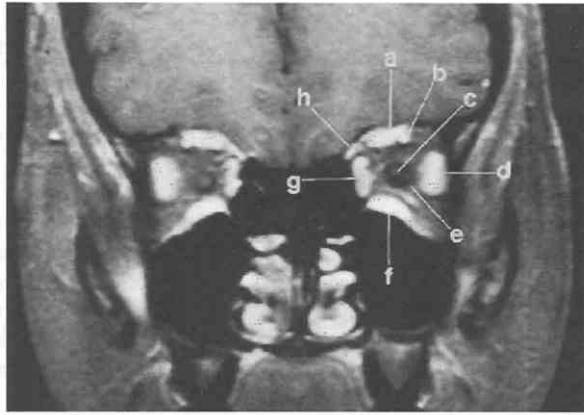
Coronal T1-weighted MRI study with fat saturation: normal anatomy. A, Superior rectus/levator palpebrae superioris complex. B, Superior ophthalmic vein. C, Optic nerve. D, Lateral rectus. E, Dural sheath. F, Inferior rectus. G, Medial rectus.
